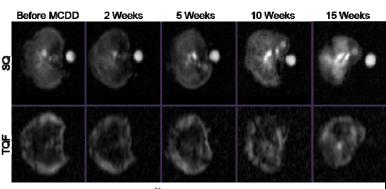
SQ (top) and TQF (bottom) ²³Na MRI before initiating MCDD and 2, 5, 10, and 15 weeks after initiating MCDD (left-to-right).
